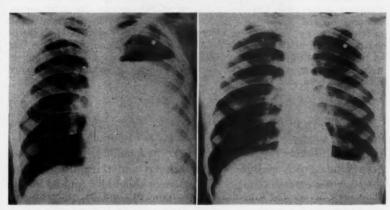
Case 2. Roentgenogram of 15 day old empyema. SK-SD begun following day. Metallic foreign body lies in shoulder girdle.
